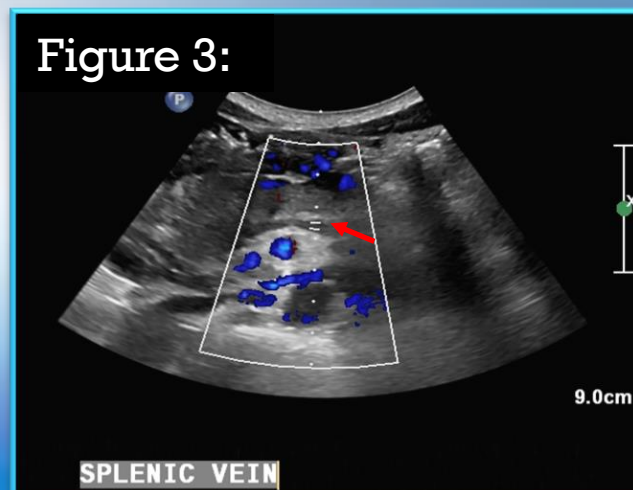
Doppler shows splenic vein thrombosis with no color flow seen (arrow).
